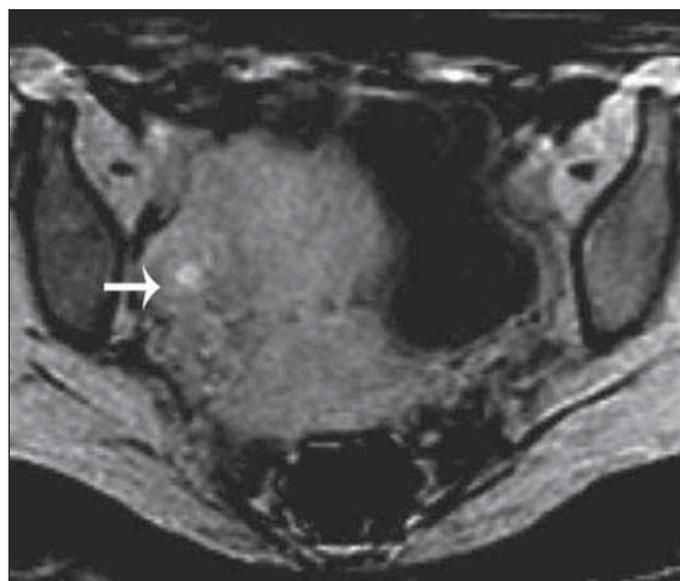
Ovarian focus of endometriosis. Axial MRI T1-weighted water-image acquired with a 0.2 T scanner, demonstrating hypersignal intensity on the right ovary.
